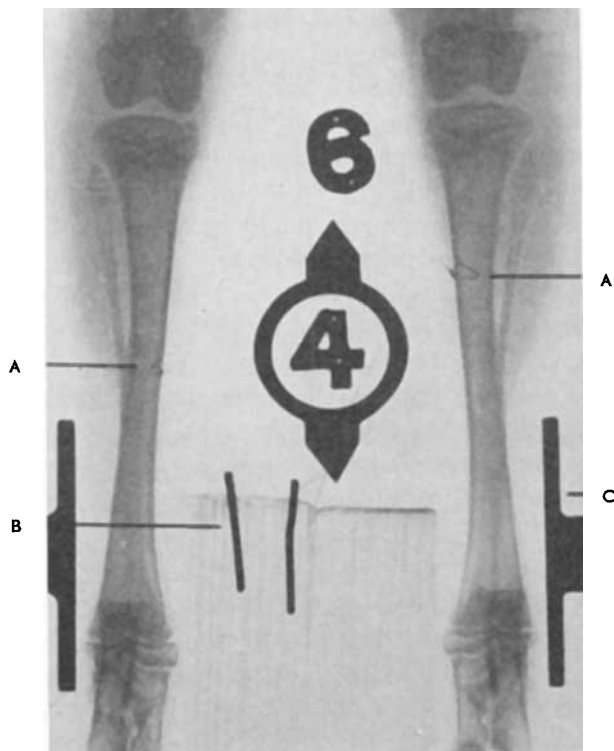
Roentgenogram of the tibiae. The indicators in the corticalis (A) are reference points for the evaluation of growth from the two epiphyseal cartilages. Metal indicators (B) are in the wooden peg (H in Fig. 3) and indicate the left side. The metal plates (C) fix the distal ends of the tibiae to the wooden peg.
